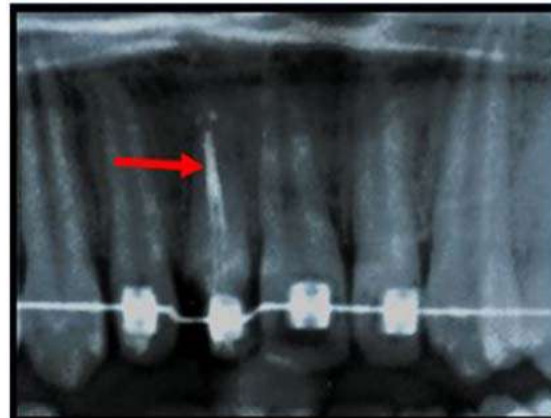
Radiograph showing extrusion of 11
